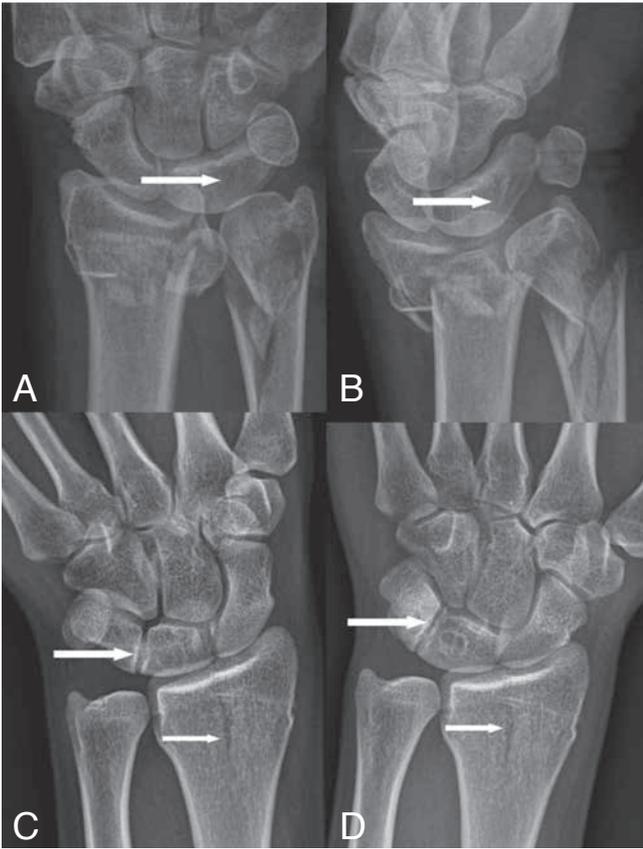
Asymptomatic variant. Plain radiography. A. and B. A LTC (arrows) type 3 was found during X-ray examination after major trauma (patient 4). C. and D. A LTC (long arrows) type 1 was found during X-ray examination after minor trauma (short arrows) (patient 5).
